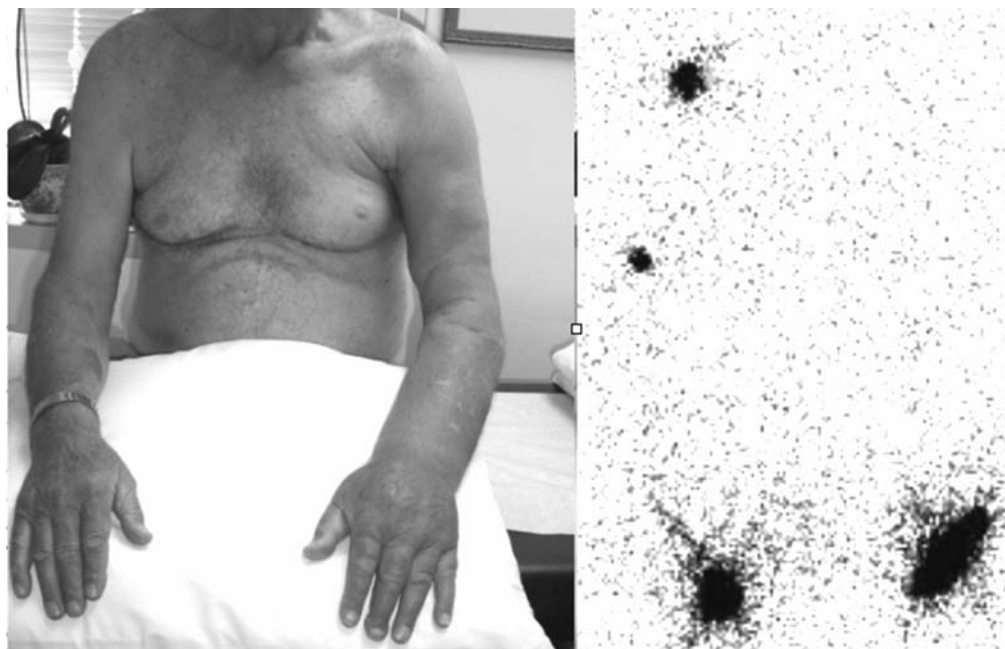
This 78-year-old man developed swelling in his left arm after axillary dissection for Merkel cell cancer. Lymphoscintigraphy (*right*) demonstrated absent lymphatic migration at 2 hours after injection on dorsum of left hand.
